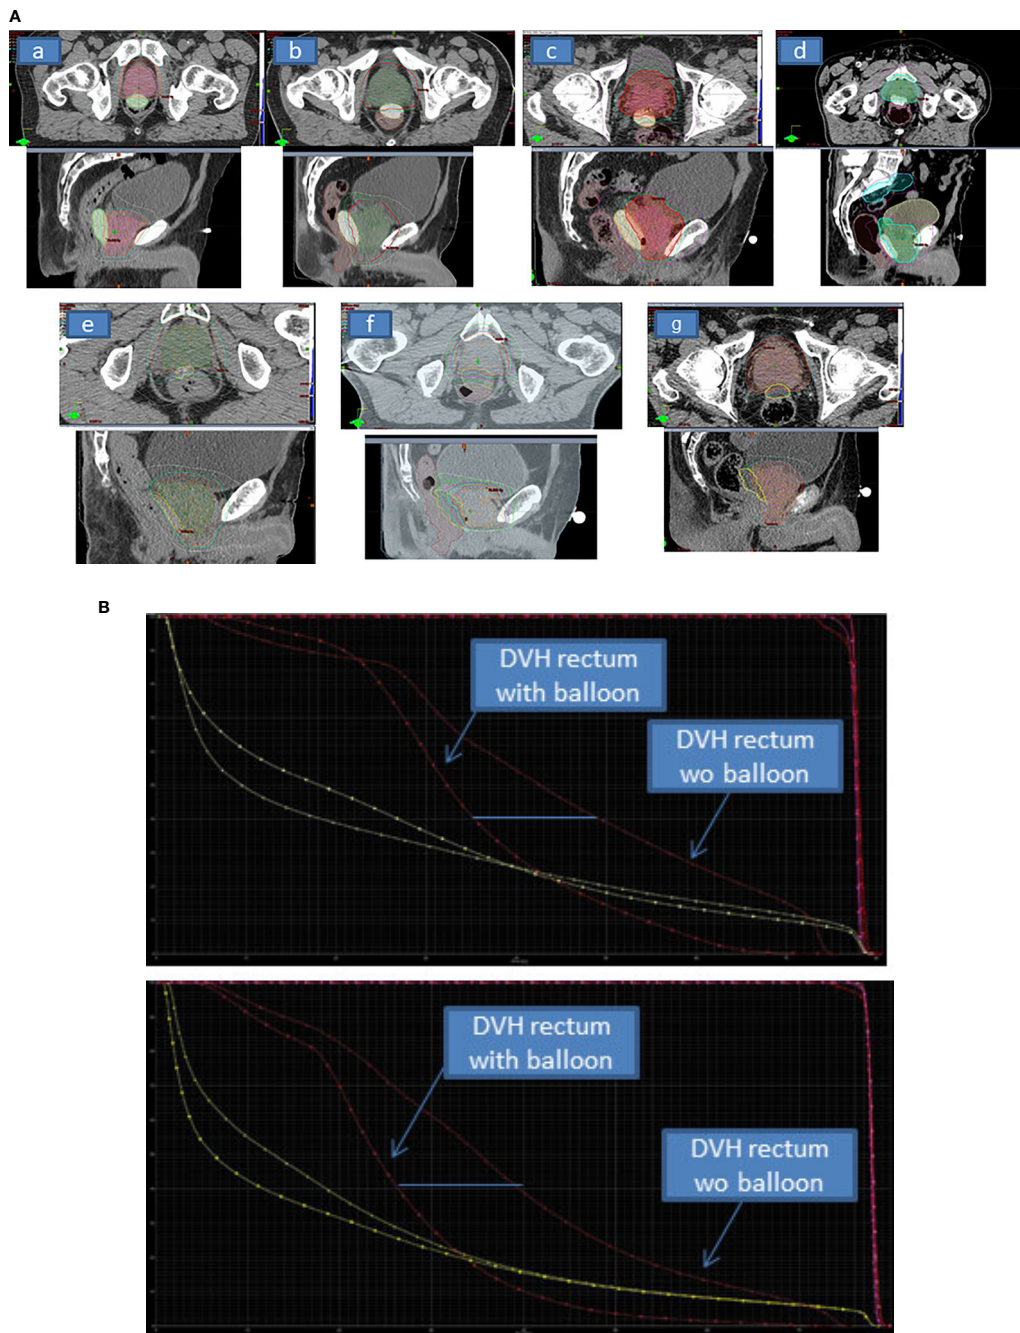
(A) The planning CT axial and sagittal views of delineated volumes of interest (prostate gland and the ProSpace® biodegradable balloon) showing good quality of delineation with iodinated contrast-filling balloon (a–g). For 1 patient (e) iodine contrast product was too much diluted. For 2 patients (f, g), the procedure was performed without iodine contrast enhancement, and so delineation of the balloon was less easy. (B) The dose-volume histogram (DVH) for the rectum pre-balloon and post-balloon for 2 patients, showing the dosimetric benefit achieved with the balloon. The DVH for bladder (also shown, in yellow) is not modified. With regard to the clinical target volume and the planned treatment volume (shown in pink and red, respectively), balloon implantation was associated with greater homogeneity.
